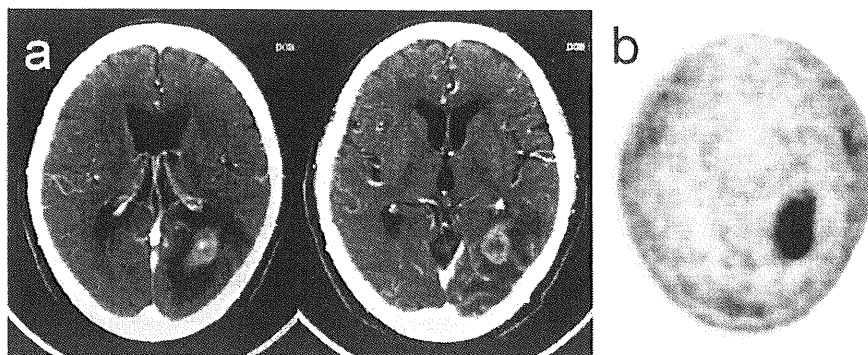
A case of malignant lymphoma of the brain. Contrast-enhanced CT of a 71-year-old patient (a) showed an enhancing mass lesion in the left temporo-occipital region suggestive of a malignant brain tumor. FLT-PET of this patient (b) showed strong FLT uptake in the tumor (SUVmax = 5.43, TNR = 18.72).
